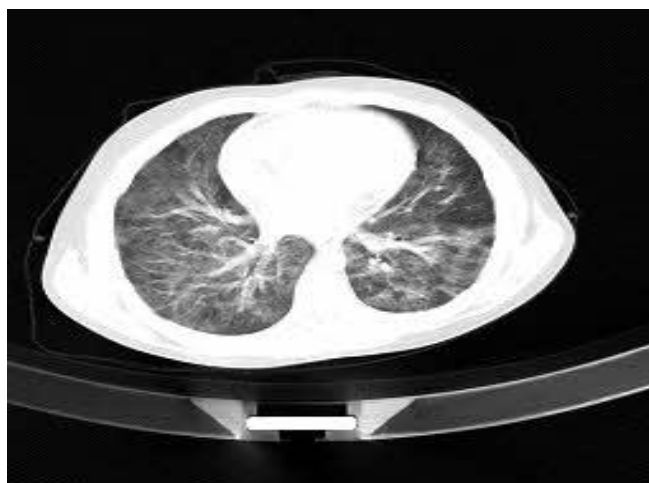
Chest CT-scan showed ground glass opacities in both lungs.
